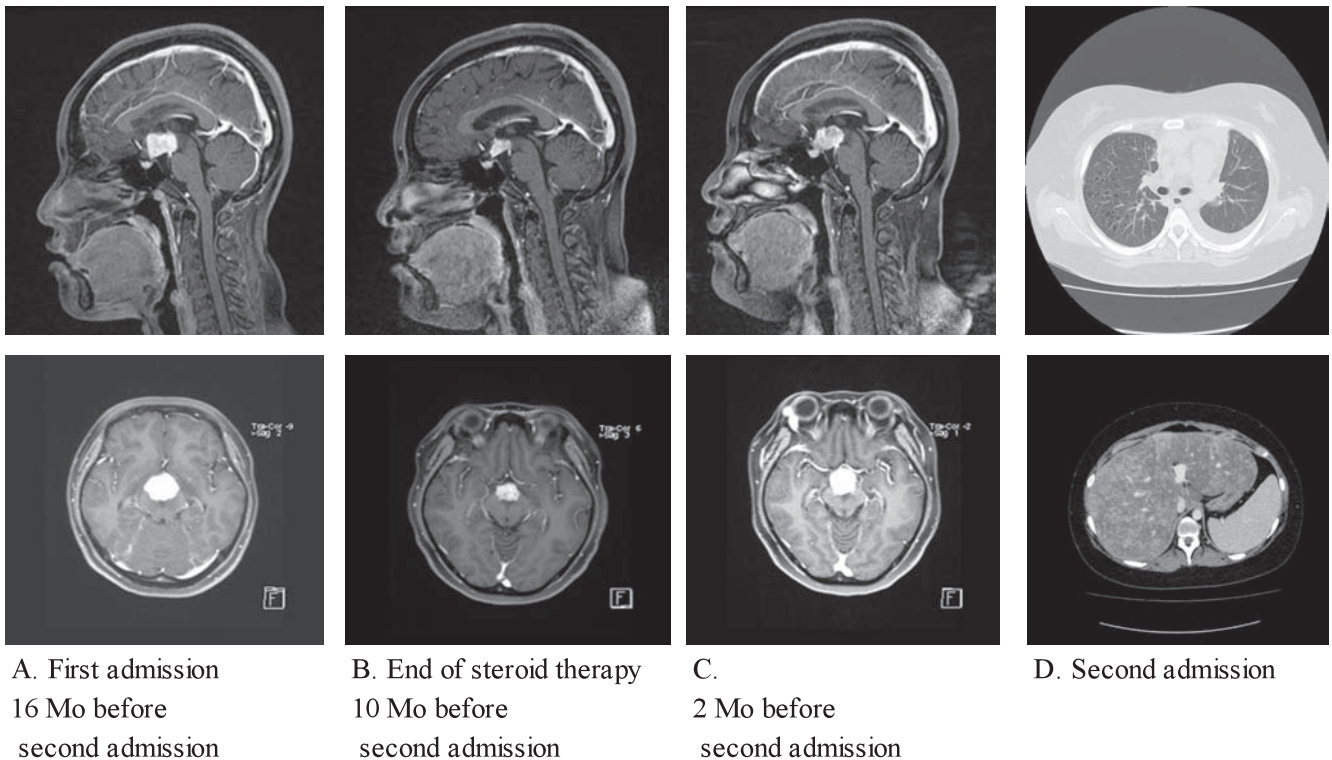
Sagittal (*upper*) and transverse (*lower*) views of Gd-enhanced magnetic resonance images (1A-1C) during the clinical course and computed tomography scan of the chest and abdomen (1D). The suprasellar mass initially shrank after steroid therapy (1B), but began to regrow after steroid reduction (1C). Chest and abdominal CT scan showed multiple diffuse low-density areas in the liver, hepatosplenomegaly, multiple lung cysts, and left pleural effusion (1D).
